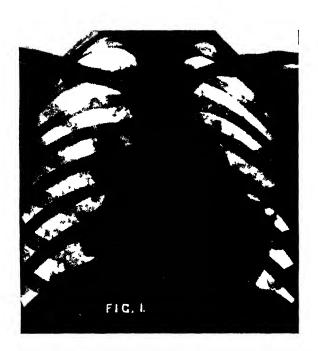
(Fig. 1) —Radiograph showing the features of a patent ductus arteriosus associated with multiple pulmonary aneury sms and infective endoc irdits
